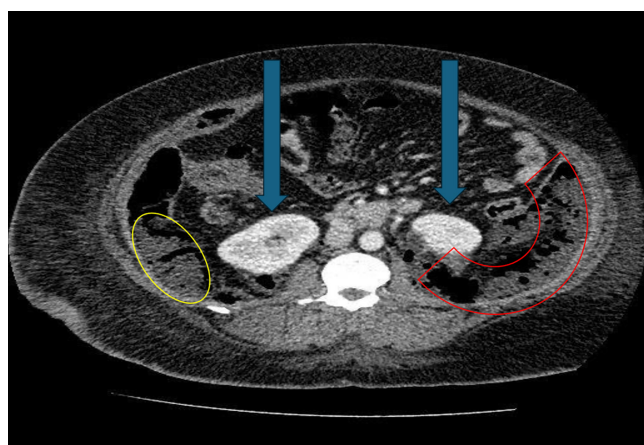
Axial abdominal CT scan view demonstrating extensive fluid collections (yellow outline) in the right paracolic gutter, and gas locules around the perinephric spaces (red outline). Arrows indicating kidneys.
